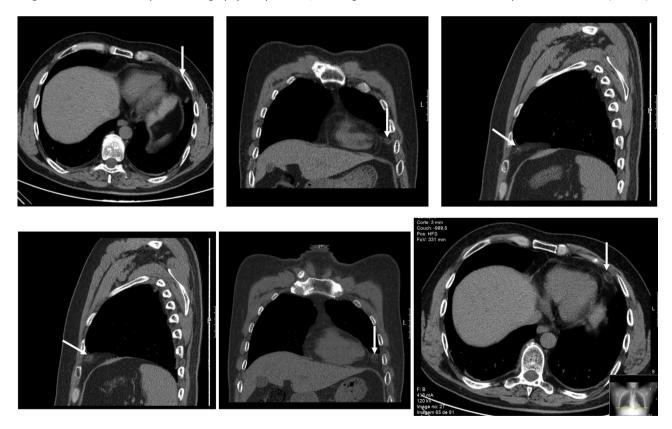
Thoracic computed tomography in July 2017, showing further reduction in the size of the paracardiac lesion (arrows).
